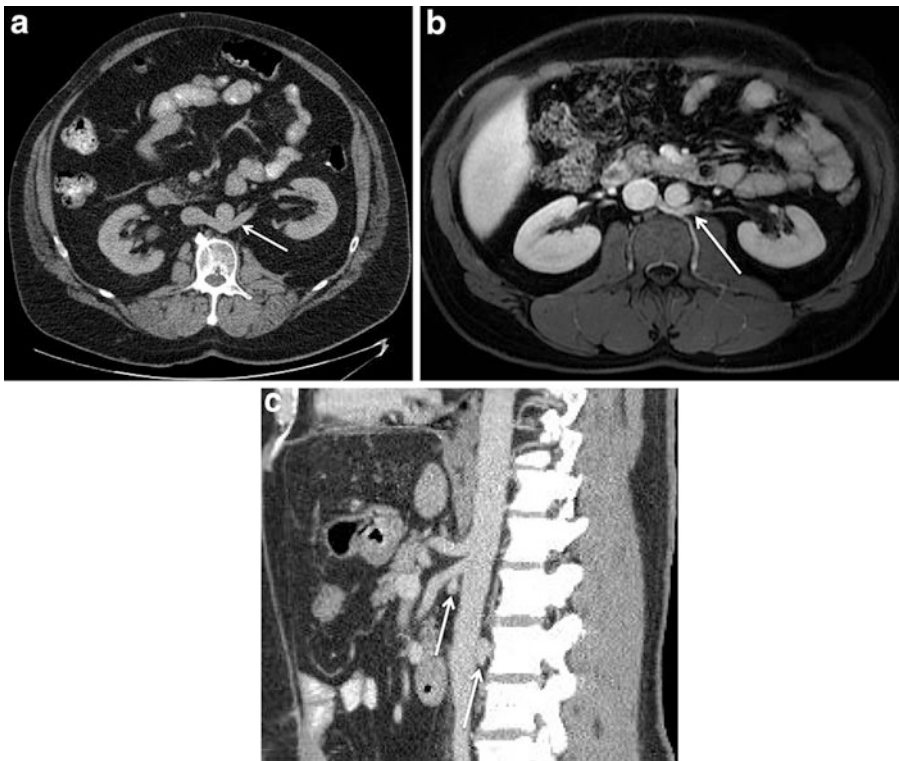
Renal venous anomalies. (a) Axial postcontrast CT image shows a retroaortic left renal vein (*arrow*). (b) In a different patient, the T1-weighted, fat-suppressed post-contrast MR image shows a retroaortic limb (*arrow*) of a
